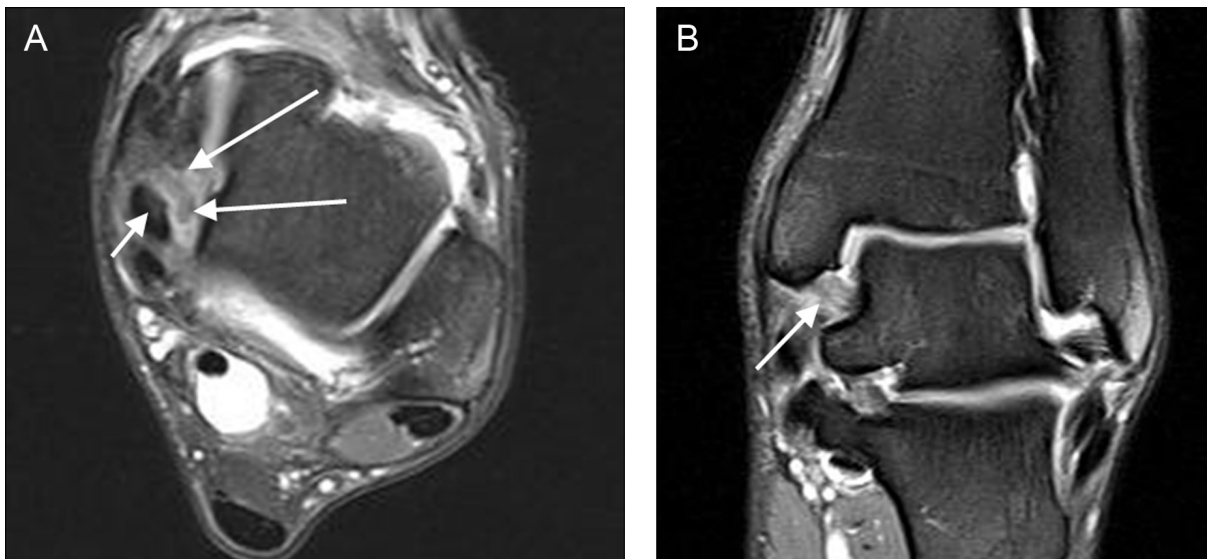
A 24-year-old male marathon runner with posteromedial impingement. (A) Axial proton density-weighted fat-suppressed MRI shows marked synovitic changes around the tibialis posterior tendon (long white arrows). Tendon itself shows intra-tendinous signal change consistent with degeneration (short white arrow). (B) Coronal proton density-weighted fat-suppressed MRI shows hyperintensity of the posterior tibiotalar ligament (white arrow) consistent with ligament oedema and loss of normal striated morphology due to remote trauma and now clinical instability. In addition, there is marked surrounding hyperintensity representing concomitant synovitis.
